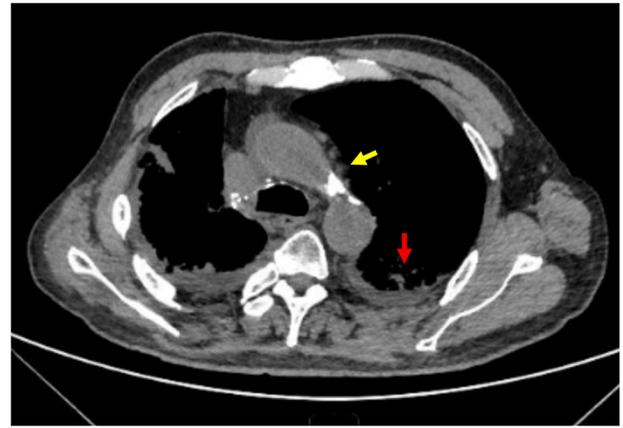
Chest computed tomography findings from January 2021. The red arrow indicates nodular pleural thickening in the left lung. The yellow arrow indicates multiple enlarged lymph nodes in the mediastinum and bilateral hilar regions.
